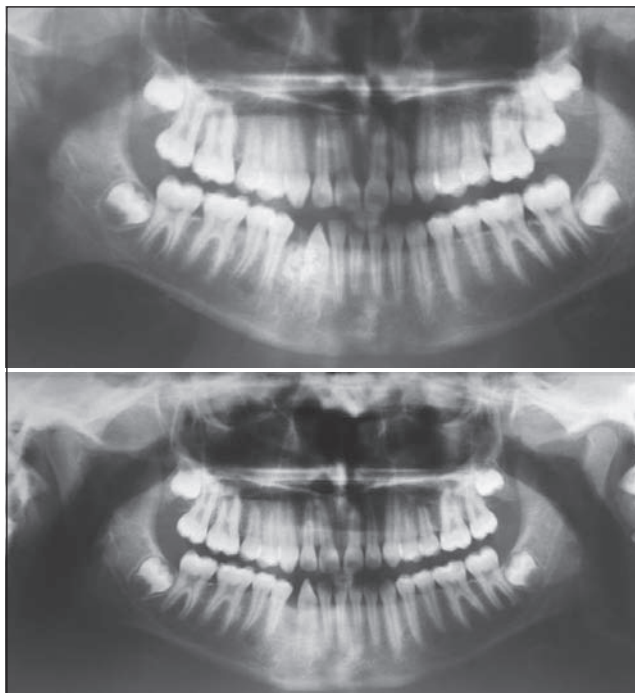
Orthopantomograph (patient J.B.) taken during the therapy with a removable appliance before the CBCT scan and three months after excision of the odontoma.
